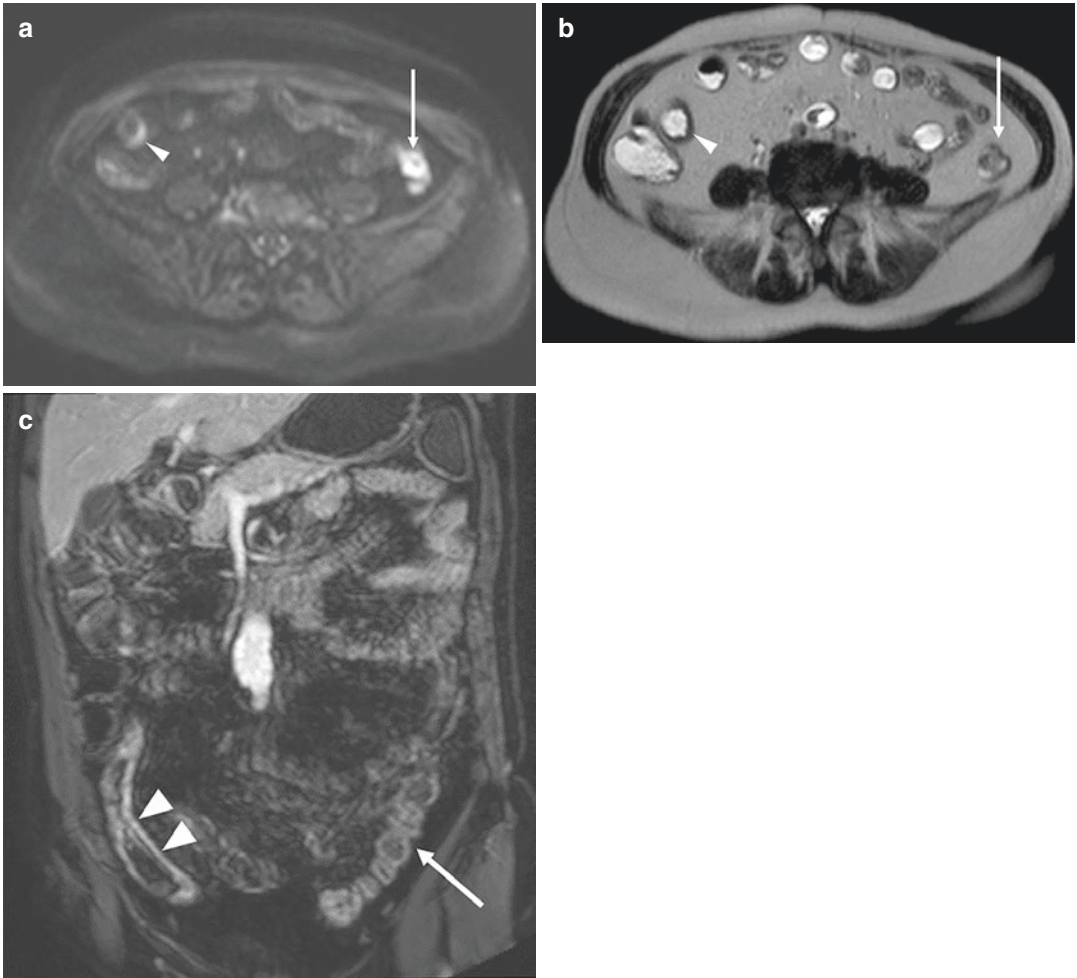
Axial DWI scan at 800 s/mm² (a) showing hyperintensity on the distal portion of the descending colon (arrow), not confirmed by axial T2-w HASTE (b) and coronal contrast-enhanced GE T1-w with FS (c). The
